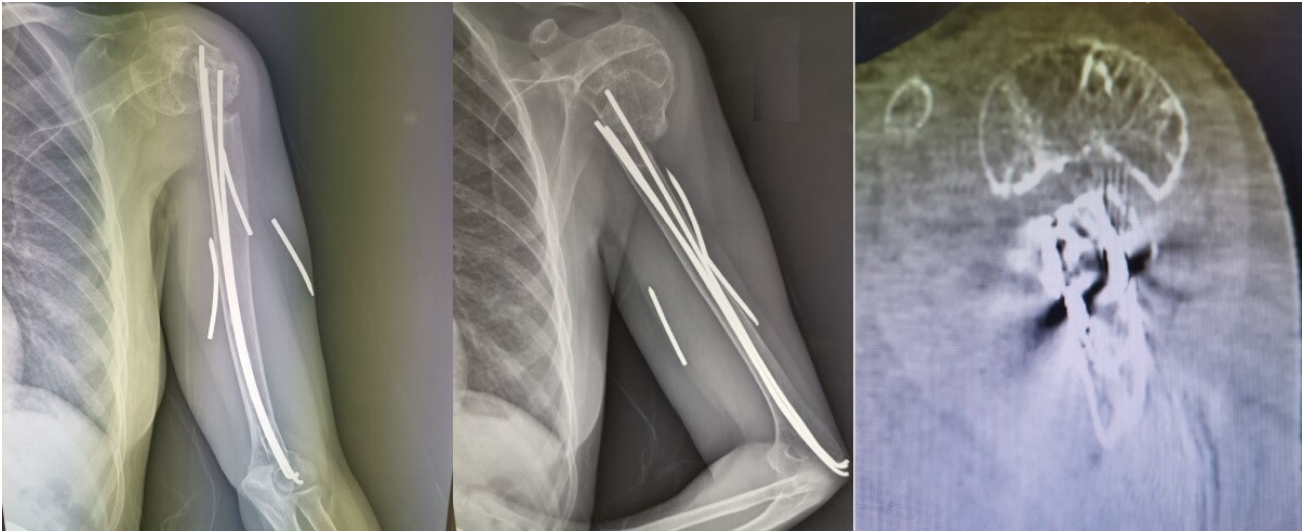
Plain X-ray and CT scan show proximal humerus fracture non-union with hardware breakage and migration, varus deformity, and radiolucent changes at the humeral head.
